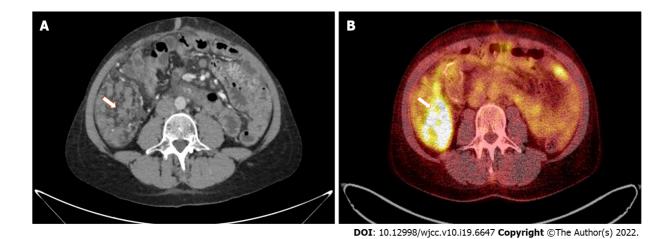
Pathological intraperitoneal infiltration (arrows) measuring 83 mm × 46 mm × 52 mm, with a standardized maximum uptake of 8.5 located in the right epigastric region, shown in computed tomography (A) and positron emission tomography (B) examinations.
